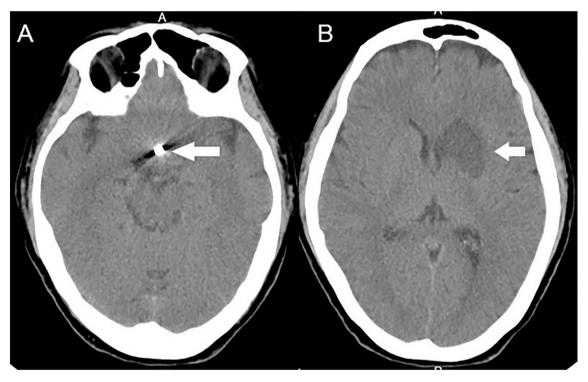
One day after operation, noncontrast-enhanced brain CT axial view showed a radiopaque material located at the suprasellar region nearby left proximal middle cerebral artery (MCA) (2A, arrow) with low density change at the left caudate nucleus, anterior limb of internal capsule and putamen] (2B, arrow).
